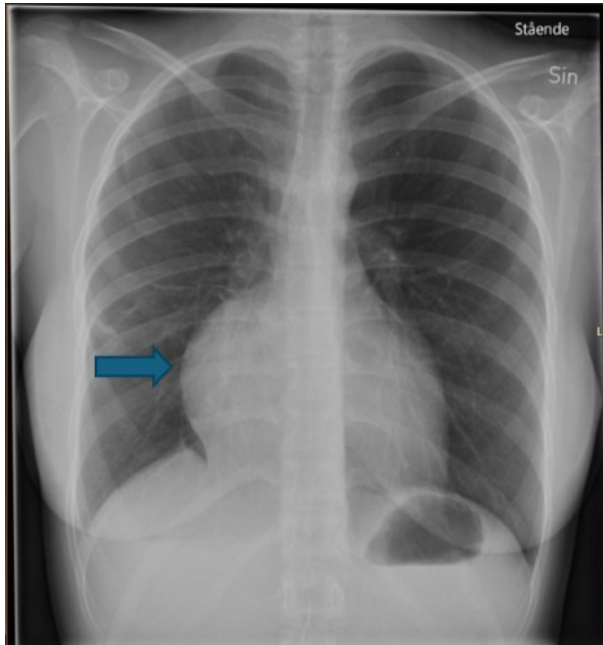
Chest X-ray showing a protrusion on the right side of the heart corresponding to the mediastinal cyst.
